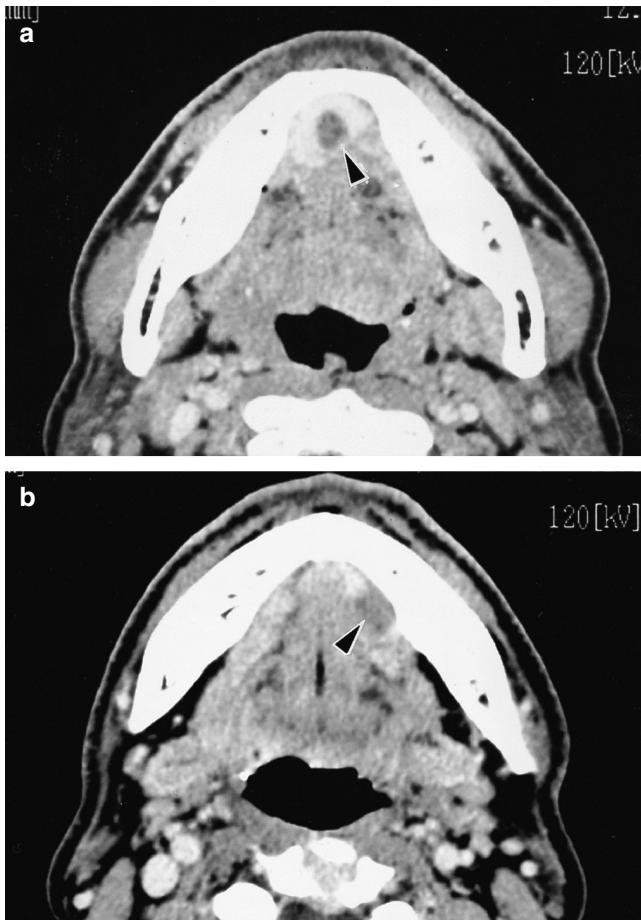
Contrast-enhanced computed tomography scan demonstrating (a) an enhancing mass with a low attenuation at a central region in the floor of mouth; and (b) a low-density lesion in the left sublingual area. Arrowheads point to the lesions.
